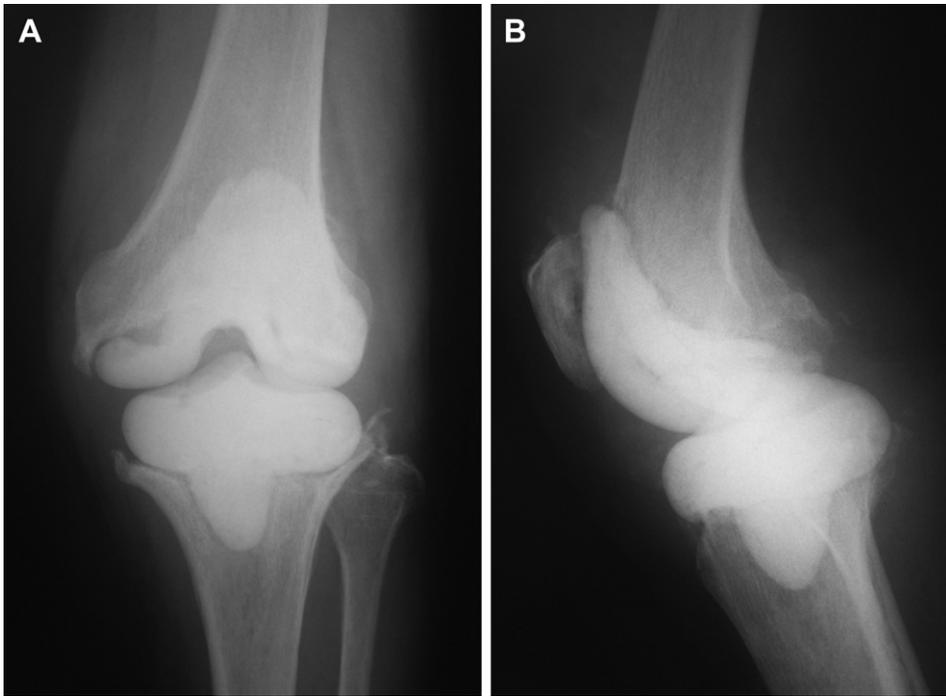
X-rays after radical debridement with insertion of antibiotic cement spacer.
